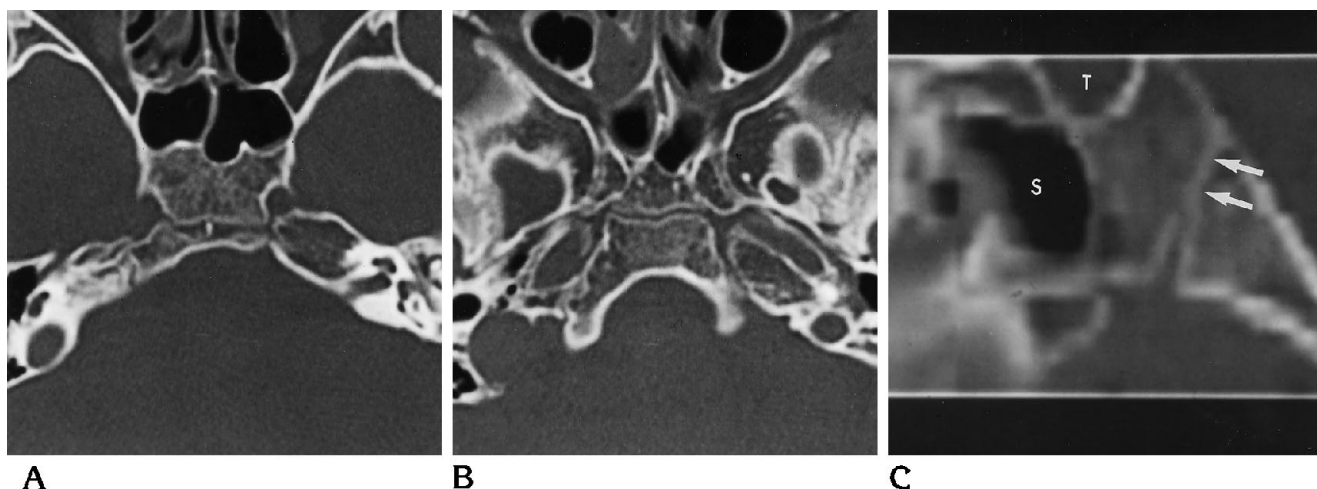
CT scans of the sphenooccipital synchondrosis in a 10-year-old girl.
